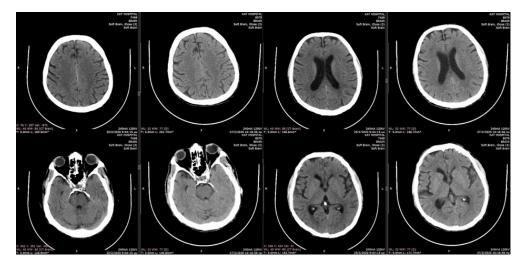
CT scans performed on presentation and 48 hours later. No vascular or structural abnormalities were observed.
